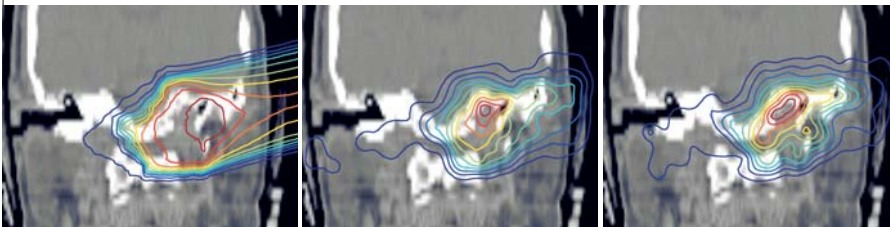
Clinical application of in-beam PET at the carbon ion therapy facility at GSI Darmstadt. As an example, the irradiation of a chondrosarcoma of the skull base with a lateral portal coming from the left side of the patient, i.e., right side in the picture (maximal dose: 0.63 Gy), is displayed. As indicated by the dose distribution superimposed onto the computed tomogram (left), the carbon ions must not penetrate the brain stem as an organ at risk. The comparison of the predicted (middle) with the measured (right) β^+ -activity distributions shows that this was fulfilled during the treatment. The isodose and isoactivity lines are decoded in rainbow colours and denote 5, 15, ... 95 % of the maxima.
